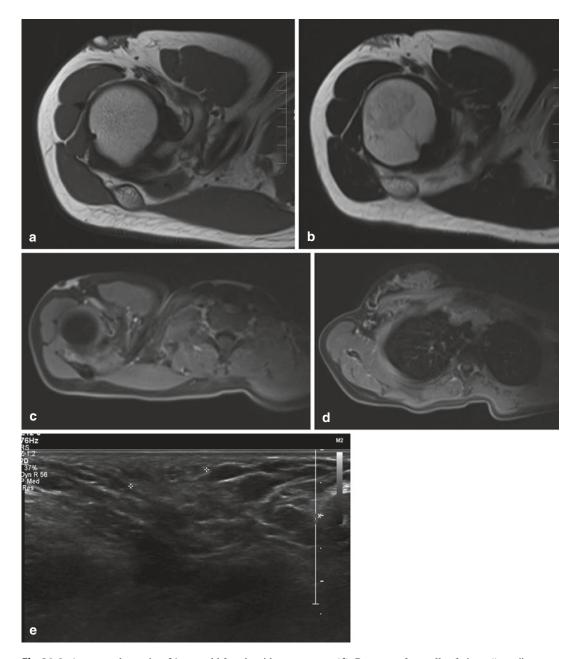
Accessory breast in a 21-year-old female with a palpable swelling in the right axilla. The lesions enlarge and are slightly painful in the second half of the menstrual cycle: (a) axial T1-weighted MR image; (b) axial T2-weighted MR image. (c, d) Axial FS T1-WI MR image before (c) and after intravenous injection of gadolinium
